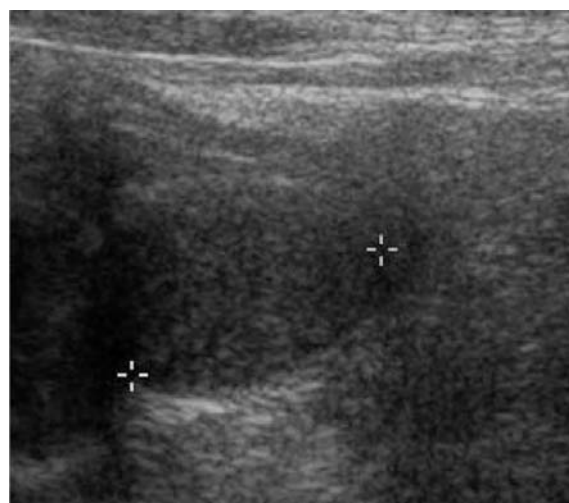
Ultrasonic image of a one-year old boy with an undescended testis. 1.7-cm hypoechoic lesion (indicated by *) in the right inguinal canal are shown by ultrasound. After inguinal exploration, the absence of right testis in the inguinal region is noted. This suggests that this hypoechoic lesion could be an inguinal node.
